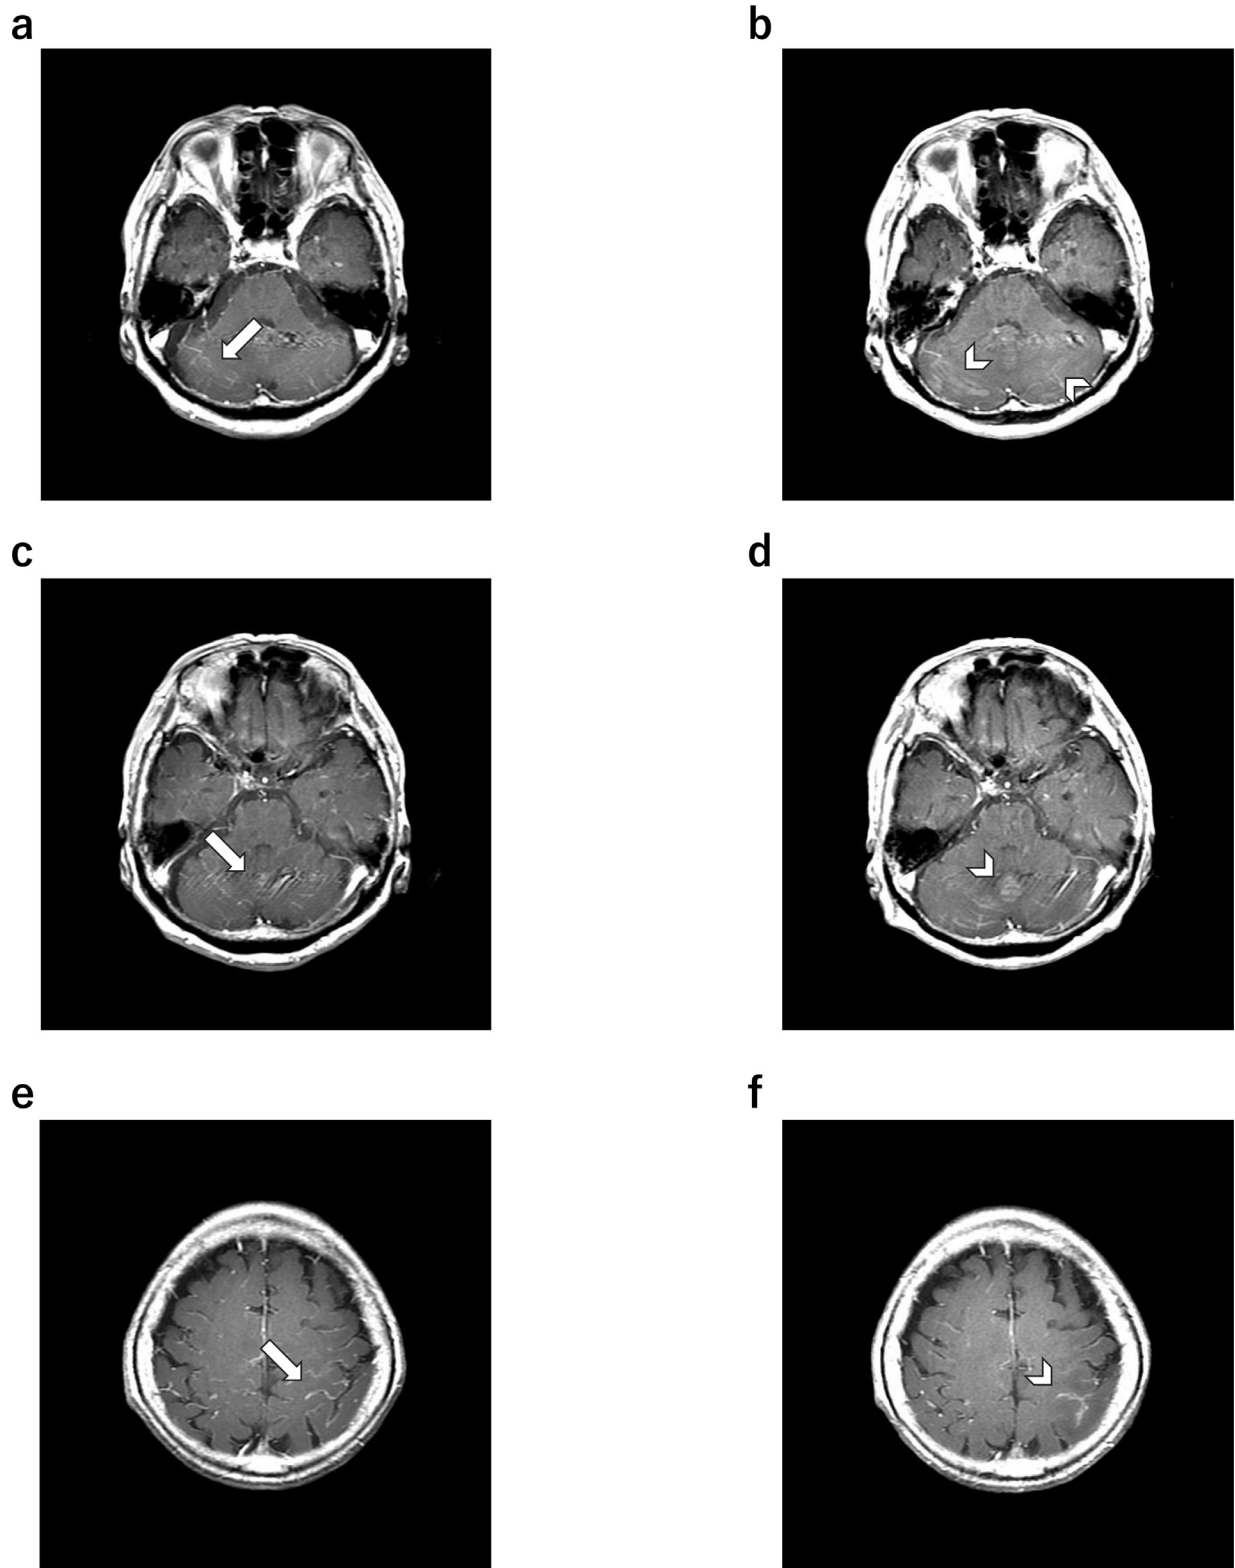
Postcontrast T1-weighted images on the day of admission (a, c, e) reveal subtle enhancement in the sulci of the cerebellum and left parietal lobe on the initial MRI (arrows). At the onset of PIRS on the 52nd day of treatment (b, d, f) there is a more conspicuous enhancement of the meninges on postcontrast T1-Weighted (arrowhead) compared with the previous images.
